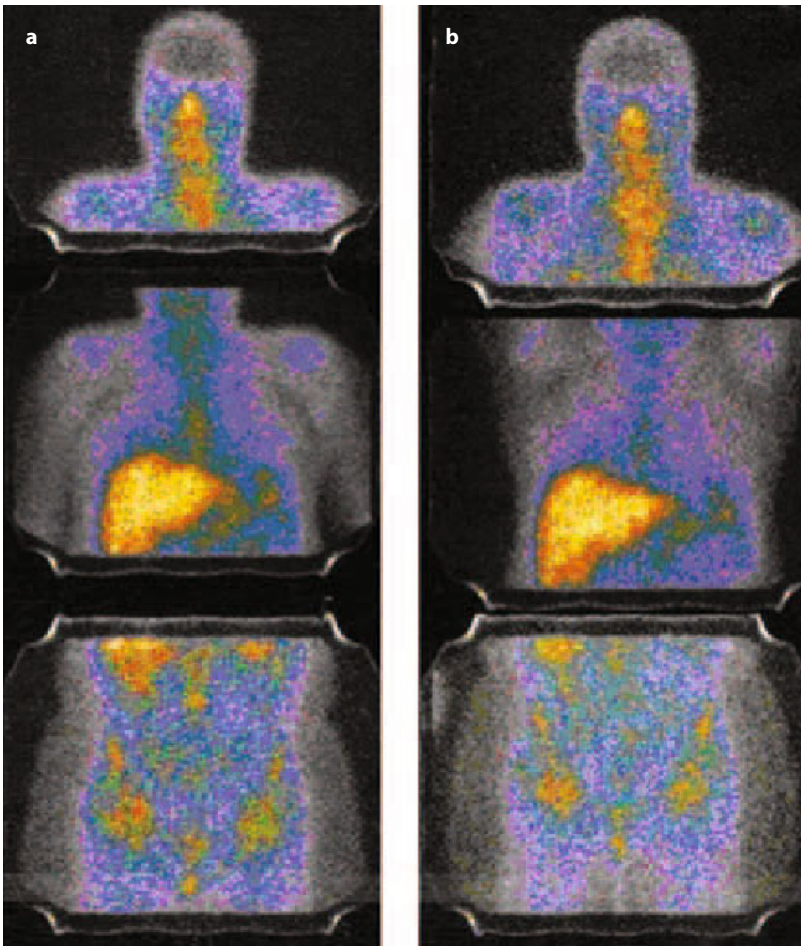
Normal ^{67}Ga -citrate scintigraphy: anterior spot views of the head/neck (*upper panels*), chest (*middle panels*) and abdomen (*lower panels*) obtained 48 hours (a) and 72 hours (b) post-injection. Physiologic soft tissue visualization, with relatively intense radiopharmaceutical uptake in the liver (*middle panels*) and mild localization in pelvic bone/bone marrow (*lower panels*). Moderate radiopharmaceutical localization in the nasopharynx can also be seen (*upper panels*)
